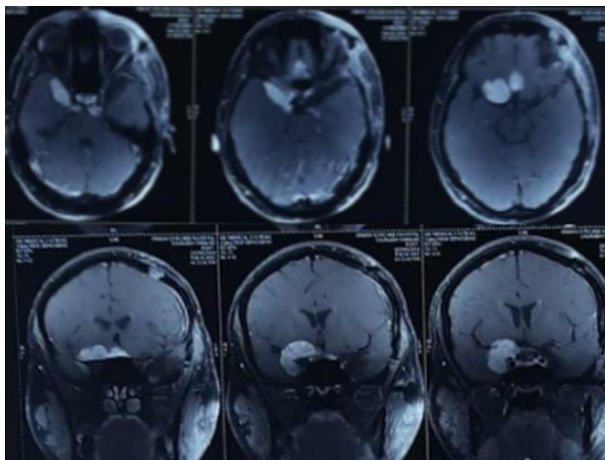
Preoperative images MRI brain with contrast before second stage surgery.
